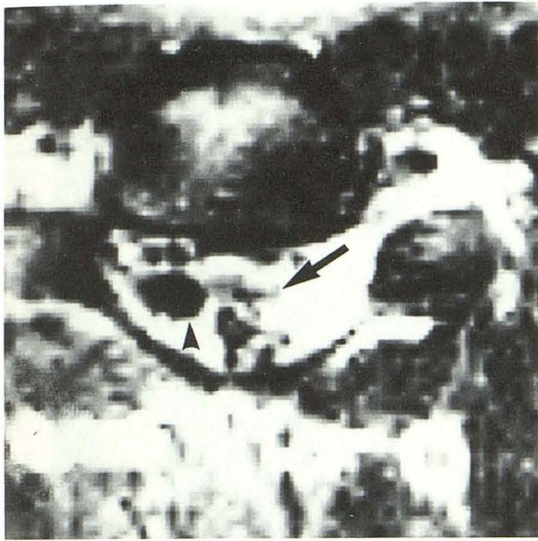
Cervical intramedullary AVM in a 30-year-old man. Transverse T2-weighted (2000/120) image. Nidus within spinal cord appears as an area of low intensity with signal void images (arrow) and extramedullary vessels outlined well by high-intensity CSF (arrowhead).
